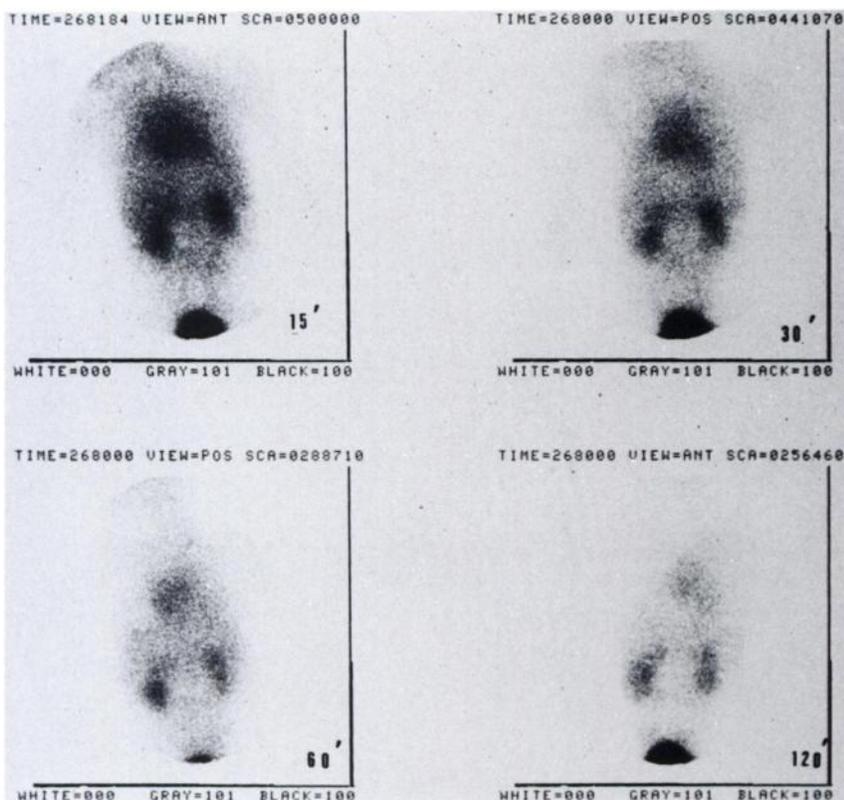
Technetium-99m-HIDA cholescintigram. The liver is not visualized and selective renal excretion of the radiotracer is demonstrated.
